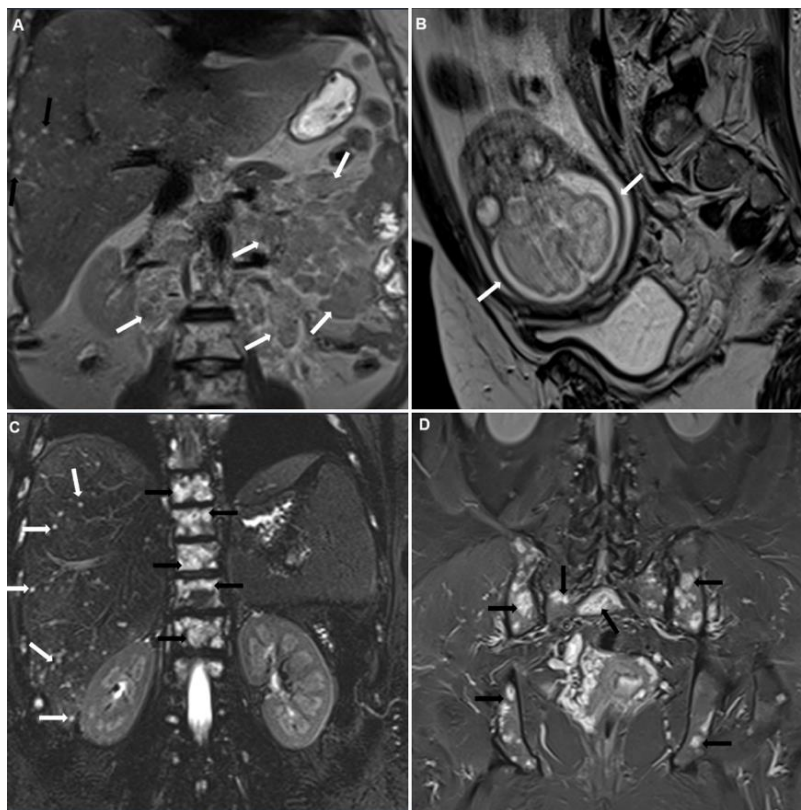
Antepartum MRI examination
